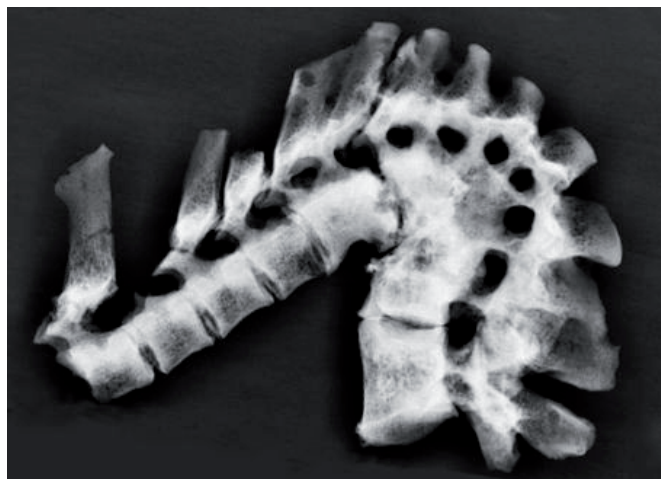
X-ray image of the spinal column (taken by Katalin K. Kiss)
